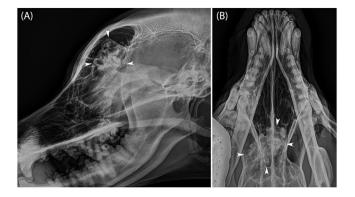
Left to right lateral (A) and dorsoventral (B) skull radiographs revealed a lobulated, heterogeneously mineralized frontal sinus mass (arrows). B, Left is to the right of the image.
